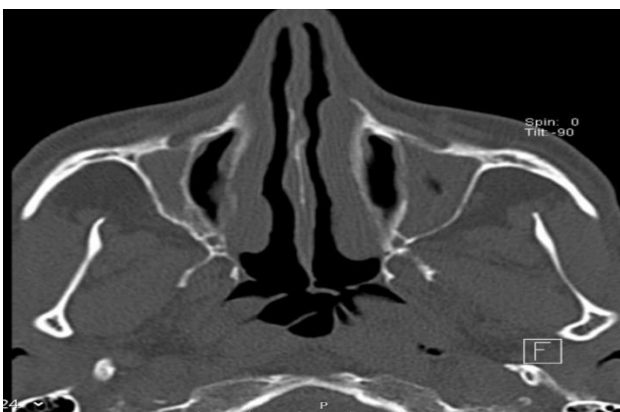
Axial view of CT scan showing a bilateral low density choanal lumen stenosis and partial nasopharyngeal obstruction.
